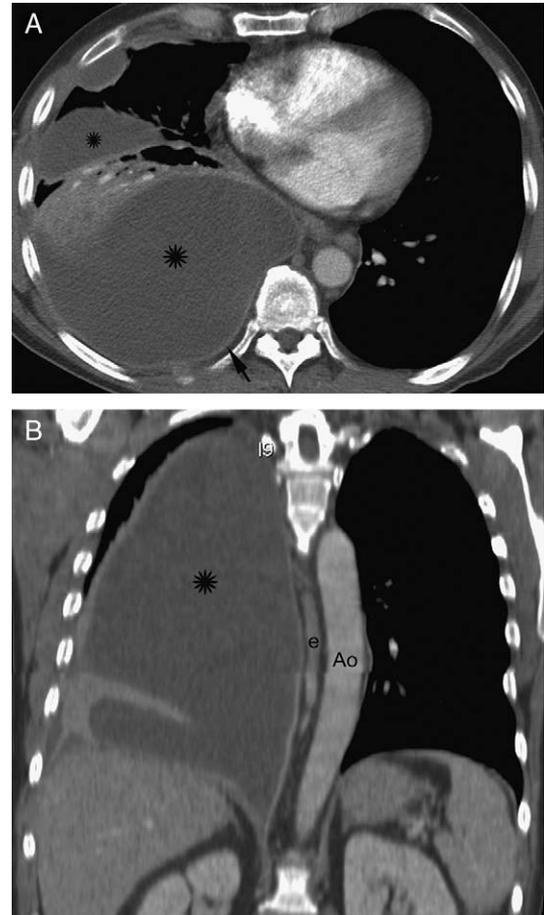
A 44-year-old male intravenous drug user with empyema. A, Contrast-enhanced CT image obtained on a multidetector CT scanner at the level of the lower lung zones shows large multiloculated right pleural effusion (asterixes). Also noted is mild thickening and enhancement (arrow) of the pleura consistent with empyema. B, Coronal image demonstrates the mass effect of the right pleural collection (asterix), causing displacement of the descending thoracic aorta (Ao) and esophagus (e) to the left. Cultures of the pleural aspirate grew *Staphylococcus aureus*.
